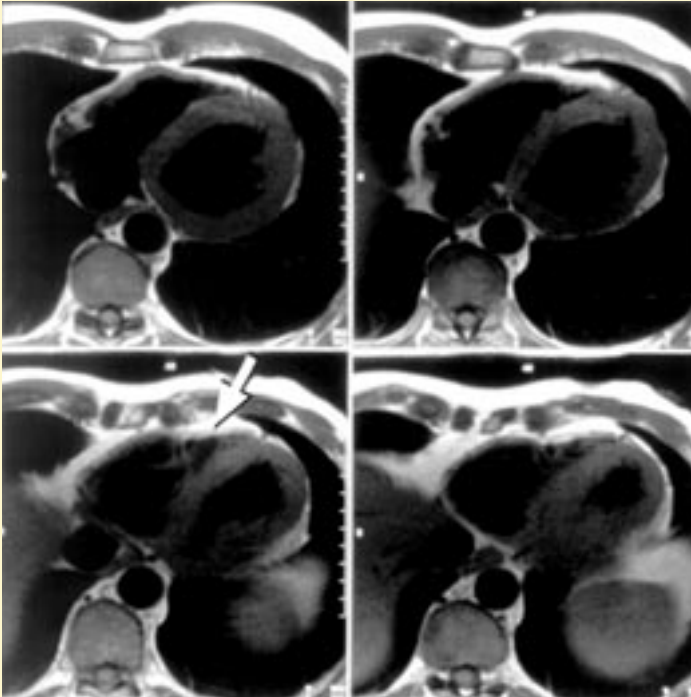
Magnetic resonance image (MRI) showing the fibrofatty distribution involving the right ventricle consistent with arrhythmogenic right ventricular cardiomyopathy (ARVC). Arrow points to fatty infiltration.
